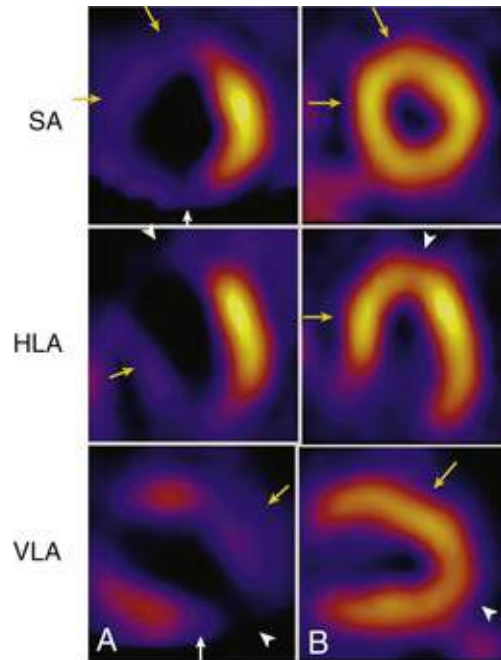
Resting SPECT perfusion imaging to assess myocardial viability. In column A, there are severe resting perfusion defects in the anterior wall and septum (*yellow arrows*), the apex (*arrowheads*), and the inferior wall (*white arrows*), all consistent with predominant infarct, in a patient with extensive CAD and severe LV dysfunction. It is not likely that revascularization would improve outcome or symptoms. In contrast, column B demonstrates images from a patient with an occluded proximal left anterior descending artery and severe hypokinesia of the subtended territories, with symptoms of heart failure and some angina. There is normal uptake throughout the anterior wall and septum (*yellow arrows*) as well as in the apex (*arrowheads*), consistent with completely retained viability. The images suggest that revascularization of the territory would be associated with improved regional function and likely improvement in symptoms. *HLA*, Horizontal long axis; *SA*, short axis, *VLA*, vertical long axis.
